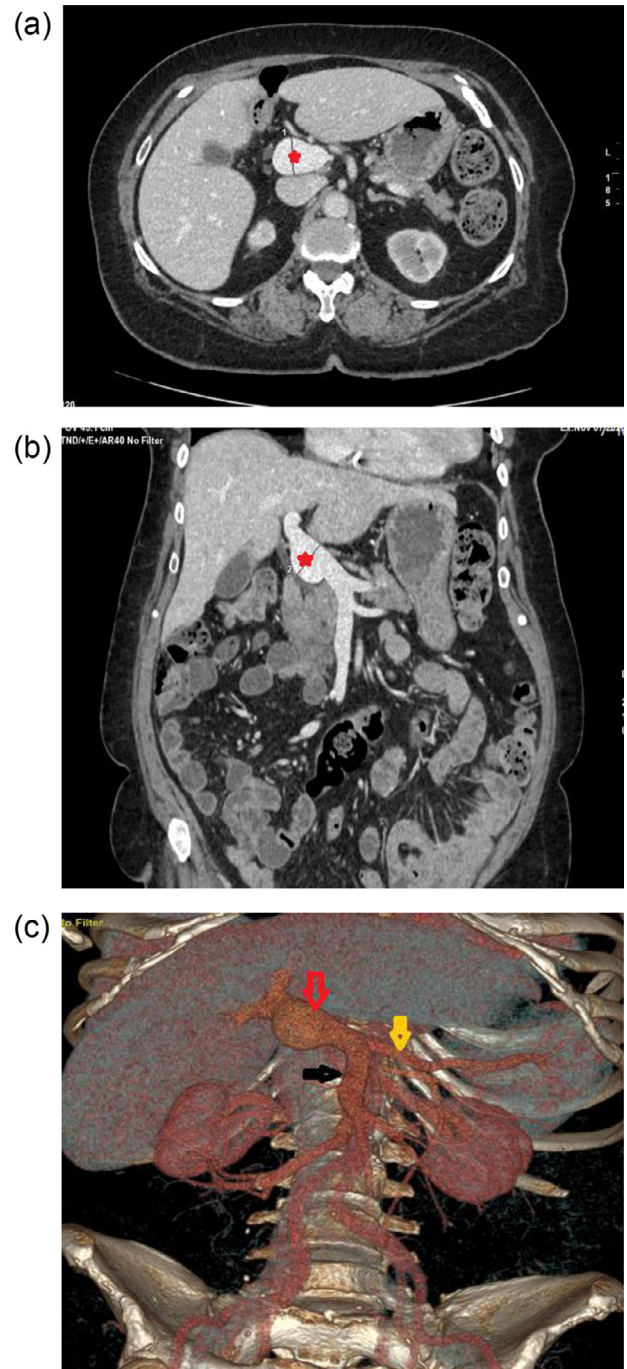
(a) Case 1-Portal venous phase CT abdomen (axial section) depicting an extrahepatic portal venous aneurysm (red star). (b) Case 1- Portal venous phase CT abdomen (coronal section) depicting an extrahepatic portal venous aneurysm (red star). (c) Case 1-3 Dimensional VR CT image depicting the formation of portal vein by combination of superior mesenteric vein (black arrow) and splenic vein (yellow arrow). PVA (red arrow).
